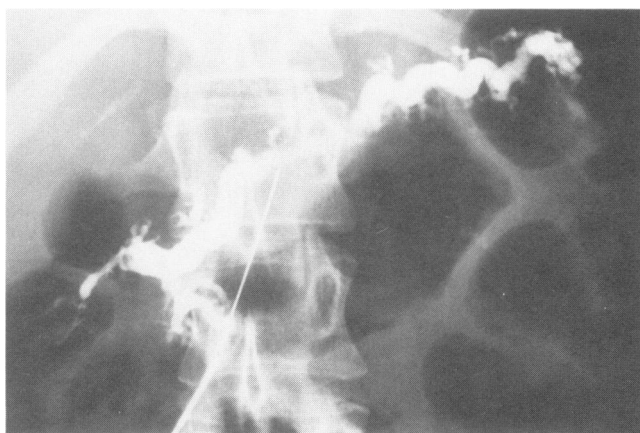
Percutaneous pancreatogram performed ultrasonographically (same patient as Fig. 3) showing typical changes of chronic pancreatitis with a dilated duct. The accessory papilla could not be cannulated endoscopically.
